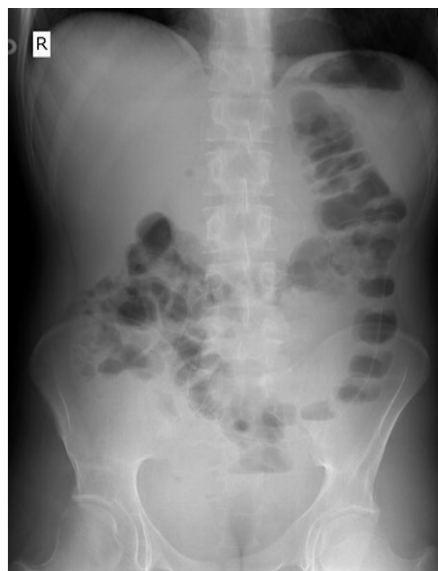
The radiograph of abdomen showing catheter in descending colon.
